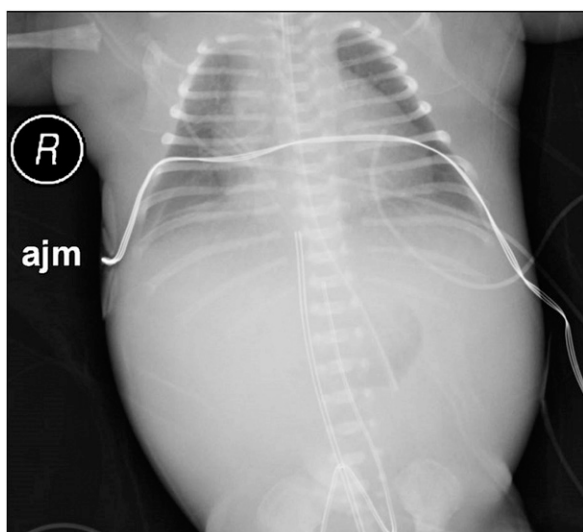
Radiograph of the chest, abdomen, and pelvis showing bilateral pleural effusions, diffuse superficial edema, and broad bands of lucency within the pelvis.
